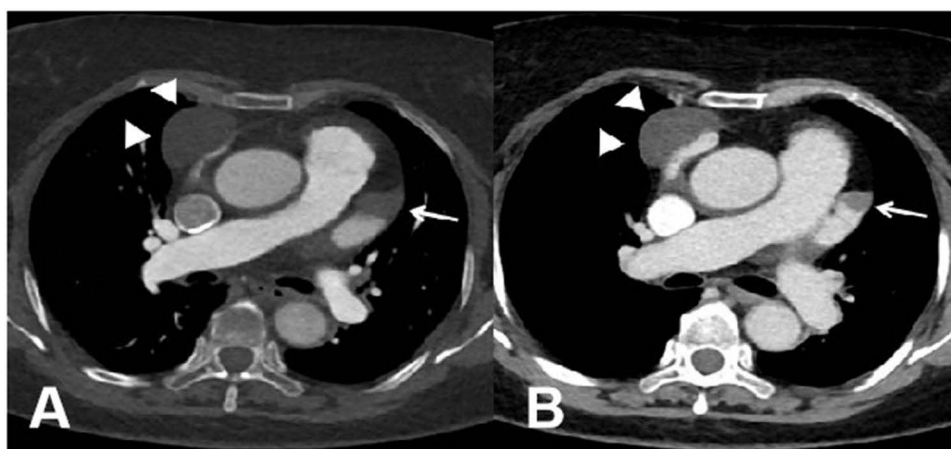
Male, 74 years old, LAA thrombosis. The distal end of LAA in the arterial phase of CTA was not fully filled (arrow), (A), and the filling defect low density shadow was found in delayed phase of LAA (arrow), (B). A cystic lesion at the right heart margin was also found (triangle), (A and B).
